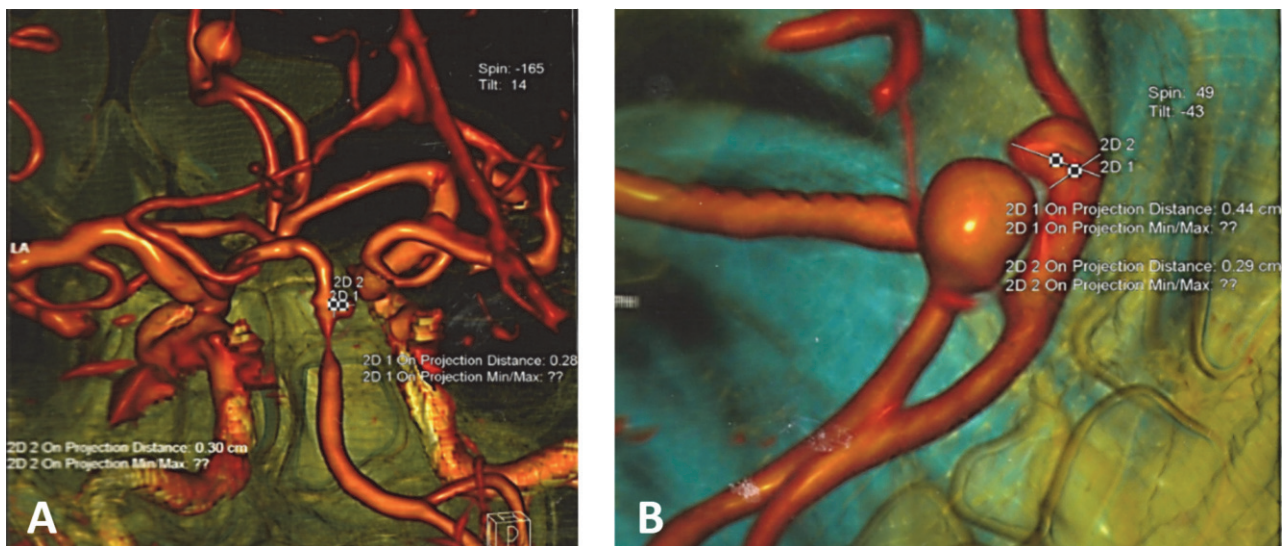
Multislice computed tomography angiography before the surgical procedure showed mirror anterior cerebral arteries aneurysms: A) anterior view; B) lateral magnified view with the smaller aneurysm measurement.
